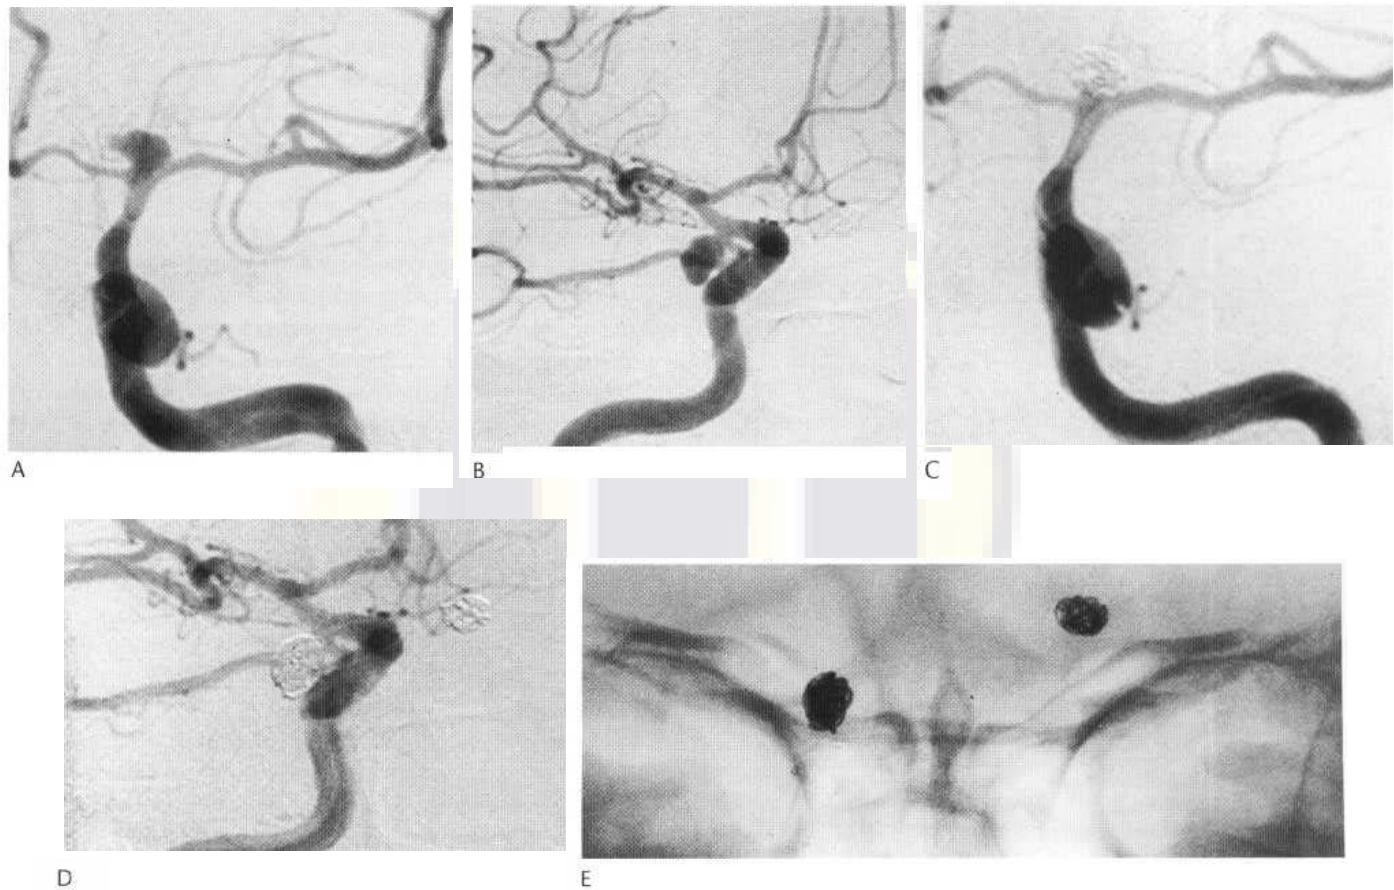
Coil embolisation of bilateral intracranial aneurysms. Left ICA angiogram (A) demonstrating a terminal carotid aneurysm. Note the nipple pointing medially, an angiographic sign often seen in acutely ruptured aneurysms. Right ICA angiogram (B) demonstrating a posterior communicating segment aneurysm. CT (not shown) had revealed the greatest density of subarachnoid blood to lie in this region. Because of the disparity between the angiographic and CT findings, it was not certain which of the two aneurysms had bled. It was therefore decided to treat both in a single sitting, despite the risk of intervention in two different arterial territories. Bilateral surgical intervention was not considered to be a safe option. Left ICA angiogram (C) demonstrates the terminal carotid aneurysm to be excluded by coils. Right ICA angiogram (D) demonstrates the posterior communicating segment aneurysm to be excluded by coils. Unsubtracted image (E) shows the position of the coils.
